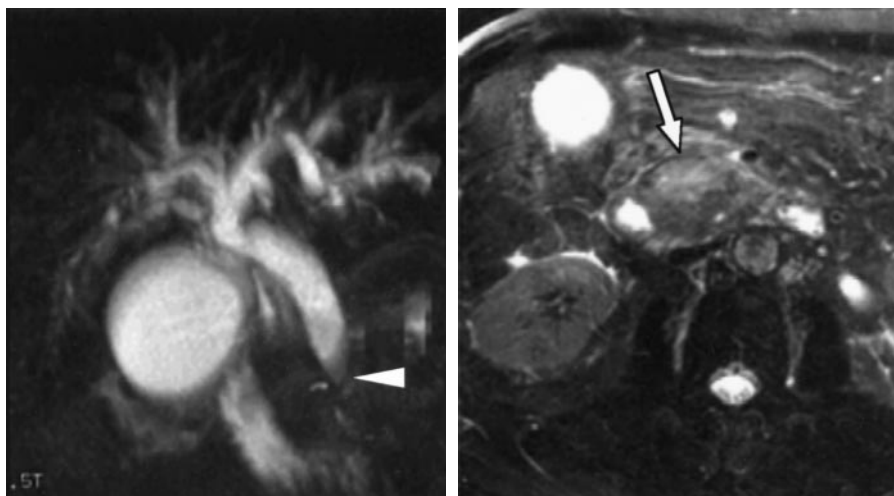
Biliary dilatation in a 70-year-old woman. (a) Coronal maximum intensity projection image reconstructed from MRCP images (fast SE, 14,000/280) shows smooth tapering of the distal common duct (arrowhead) with moderate dilatation of the biliary tree. Differentiation of benign from malignant cause was difficult on MRCP images alone. (b) Transverse less heavily T2-weighted image (fast SE, 10,909/120), (c) transverse precontrast in-phase GRE image (140/4.2), and (d) transverse postcontrast opposed-phase GRE image (120/2.5) clearly show a pancreatic head carcinoma (arrow), which was confirmed at surgery.
